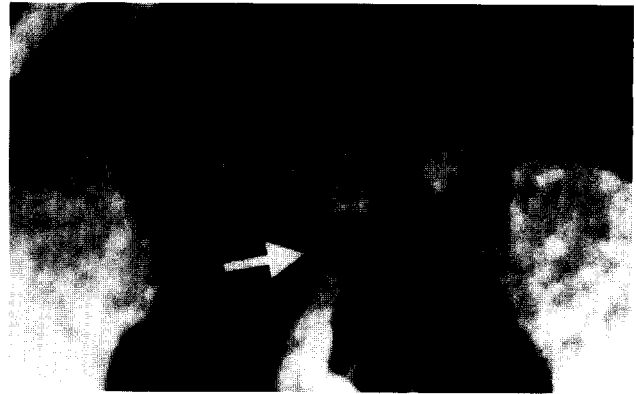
Three-dimensional reconstruction of a CT angiogram showing a grade 2 lesion with flattening on one side of the vessel (*arrow*).
